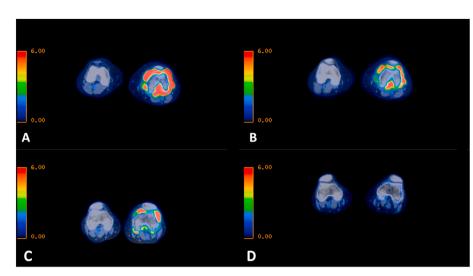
A&B Short term follow-up, fused axial PET-CT images of both knees corresponding with patient 17 in Fig. 4.
